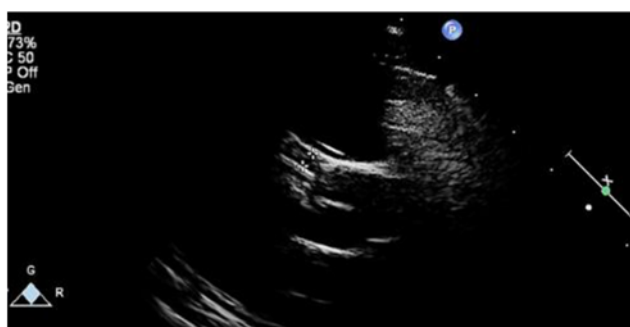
Right coronary artery aneurysm showing regression during subsequent echocardiograms.
